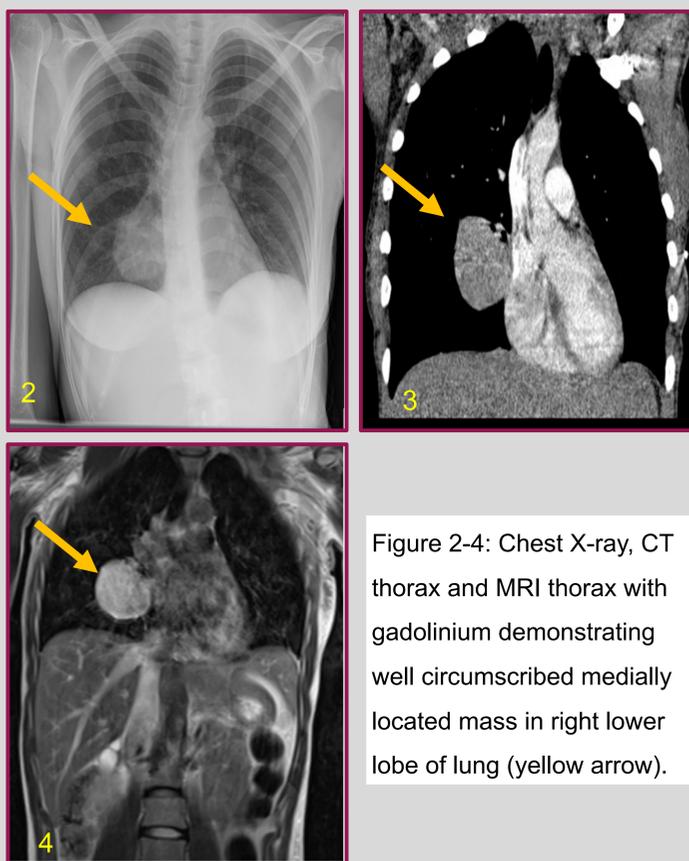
Chest X-ray, CT thorax and MRI thorax with gadolinium demonstrating well circumscribed medially located mass in right lower lobe of lung (yellow arrow).
